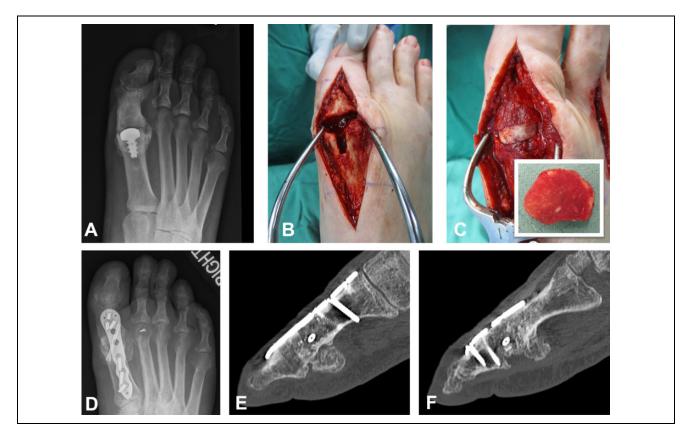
(A) An example of the use of a stem cell allograft. The patient is 49-year-old man with a failed first metatarsophalangeal (MTP) joint arthroplasty. A first MTP joint arthrodesis was performed. (B) There was a 5-mm gap that was (C) filled with an iliac crest allograft (C) from which (insert) the cancellous center was removed and packed with a stem cell allograft product. Arthrodesis was achieved by 4 months after surgery, as can be seen on (D) an anteroposterior radiograph and (E, F) computed tomography scan imaging.
